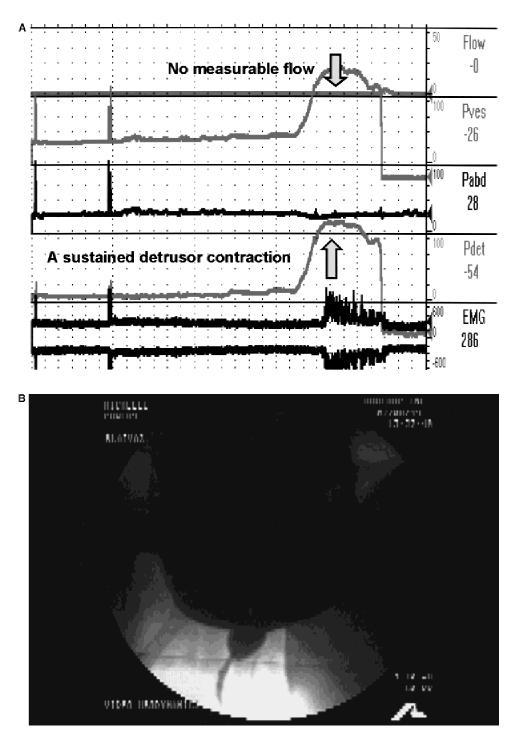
A 27-year-old woman with a 2-year history of intermittent obstructive symptoms. Repeated uroflow measurements yield varied results with some "normal" flow rates (free Qmax: 18-24 mL/s; uroflow pattern: continuous) and some low uroflows (free Qmax: <12 mL/s). However, a pressure-flow study (A) with simultaneous imaging of the bladder outlet (B) revealed distal urethral obstruction. Final diagnosis of urethral diverticulum was made by magnetic resonance imaging.
